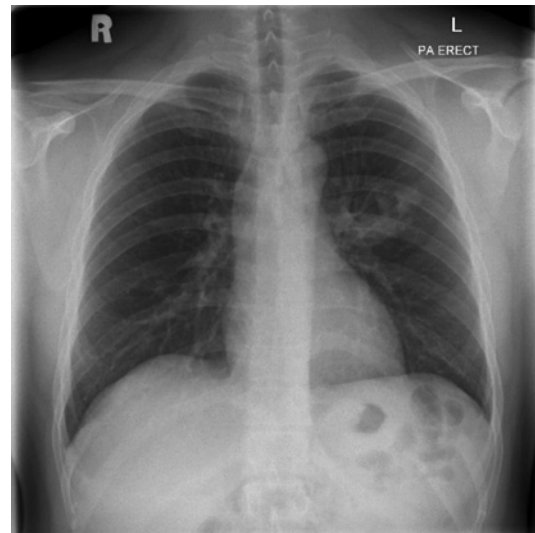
Chest X-ray: An irregular opacity in the right middle zone.
